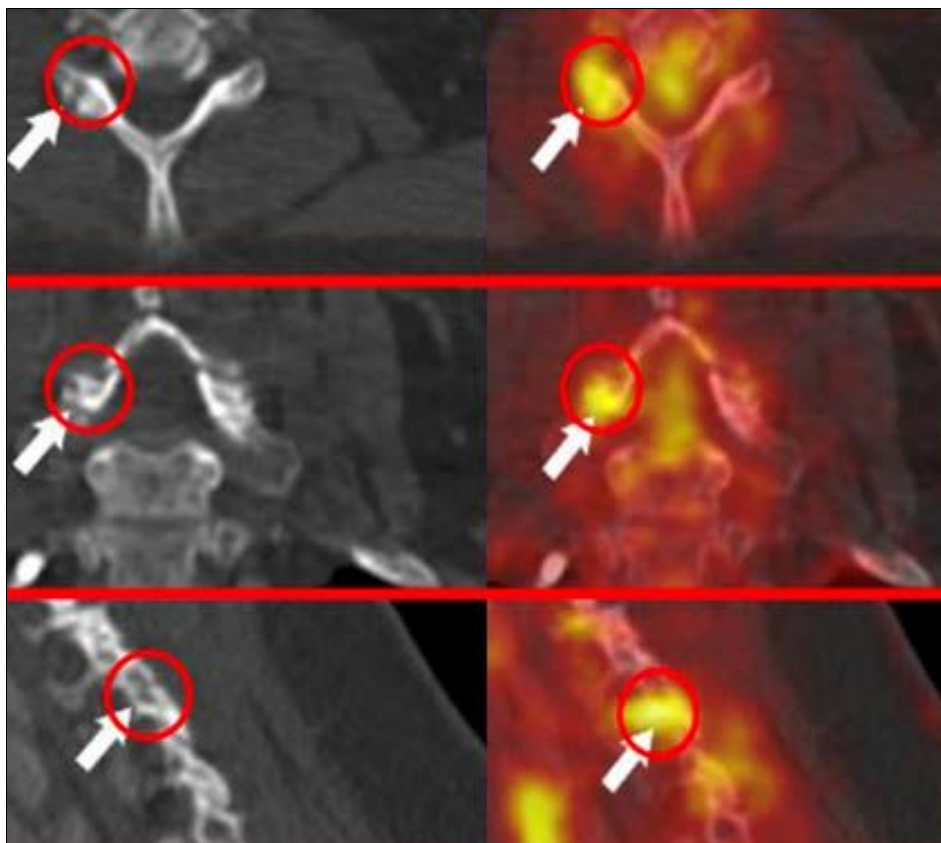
Rise in ^{18}F -FDG uptake, arrows pointing to right c6/c7 facet joint without any underlying CT alterations
